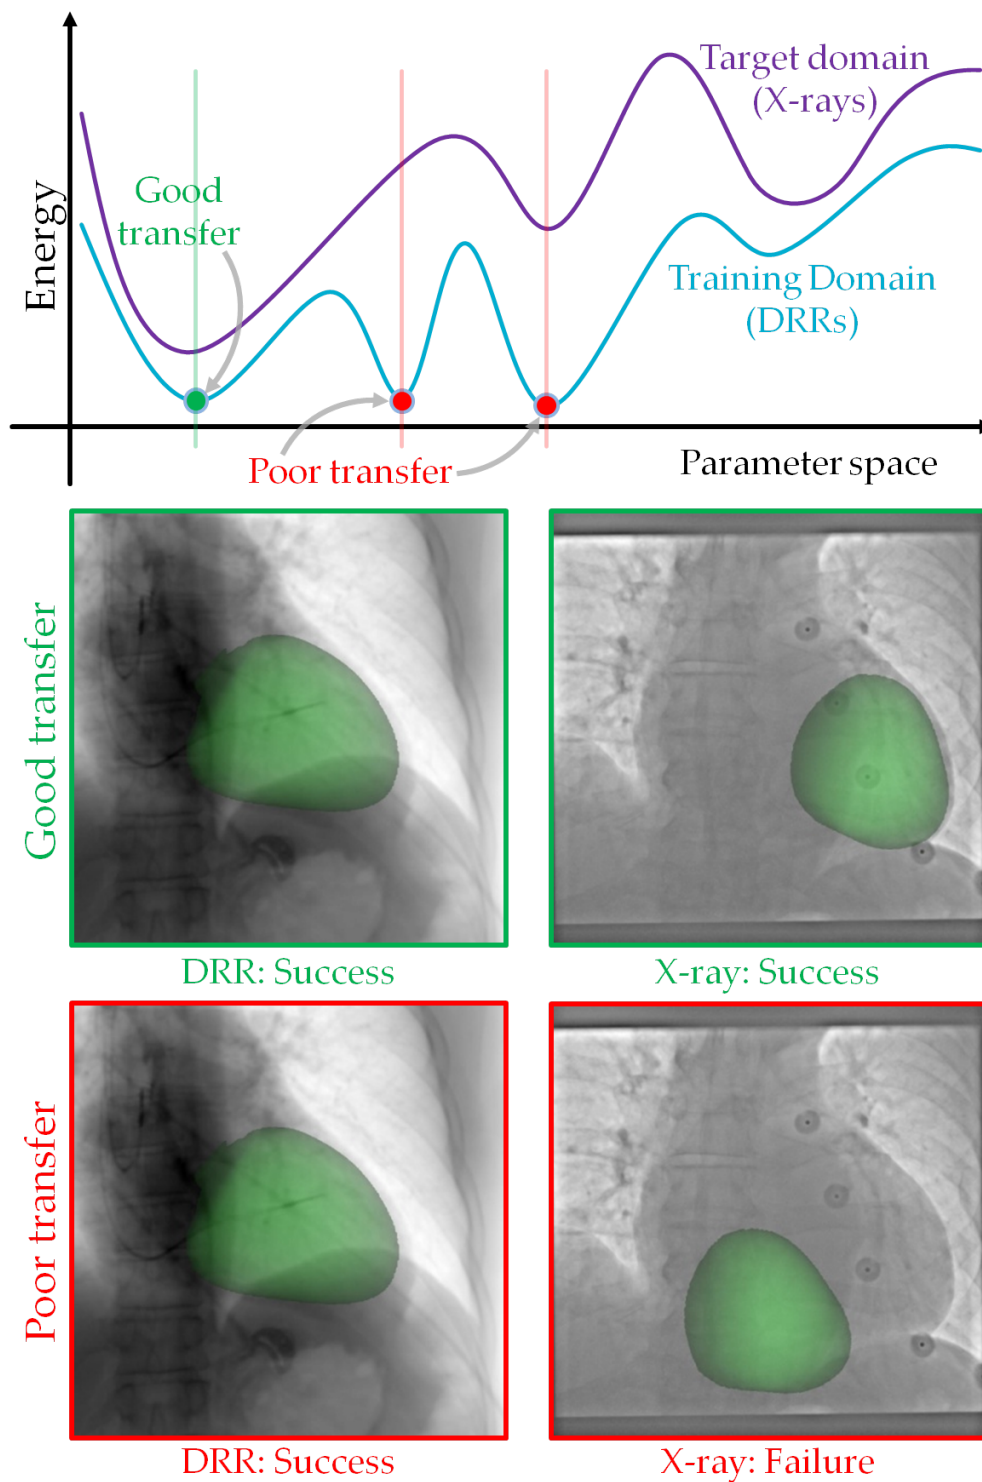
Domain transfer performance can be parameter-dependent. Training the agent on DRRs (blue) can result in highly similar local minima for different training parameters. The found minima may not correspond to minima of the loss on the target domain (X-rays) (purple). One minimum (green) of the DRR energy landscape corresponds to a minimum of the target domain's landscape. Transfer performance will be high for this minimum: optimal results on both domains. However, low for other minima (red): high performance only on DRRs.
